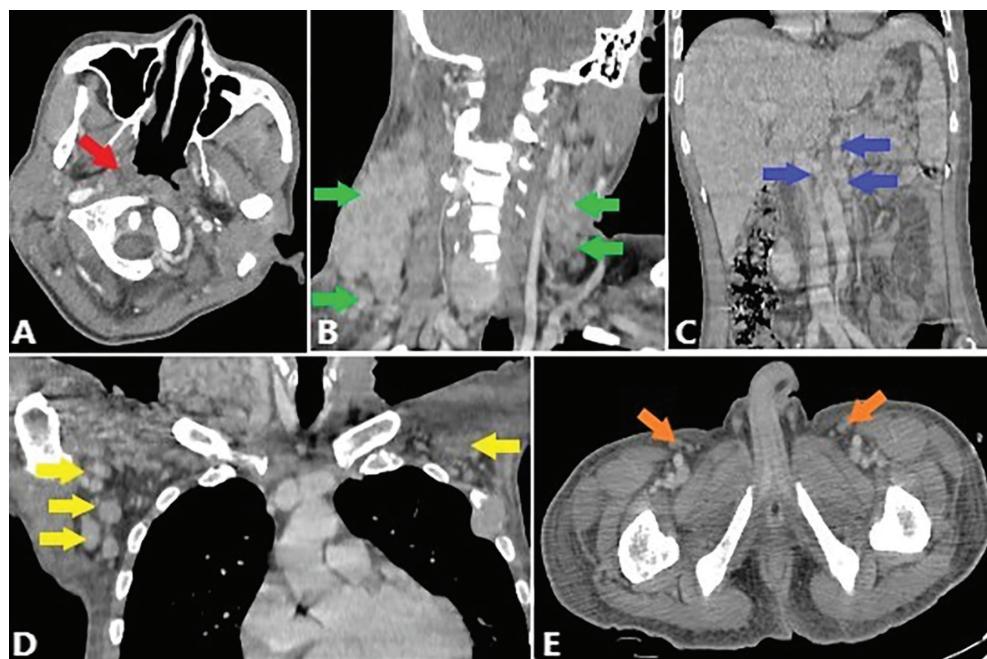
Contrast-enhanced CT scan of neck, thorax, abdomen, and pelvis. An axial image at the level of the nasopharynx shows mild thickening of the right torus tubarius compared with the left side and effacement of the right FOR (red arrow), with no enhancing lesion seen (A). A coronal image of the neck shows bilateral cervical nodes at levels II, III, IV, and V (green arrow; B). A coronal image of the abdominal region shows multiple enlarged para-aortic LNs (blue arrow; C). A coronal image of the thorax shows multiple enlarged axillary LNs (yellow arrow) (D). The axial image of the pelvis (E) depicts bilateral inguinal LN enlargement (orange arrowhead).
